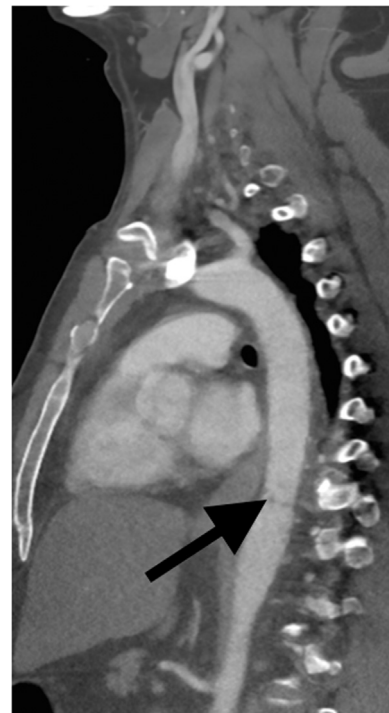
CT angiography of a patient who fell from a ladder with minimal aortic injury. Sagittal reconstruction image shows low attenuation thrombus within the aorta at the level of the diaphragm (arrow).
